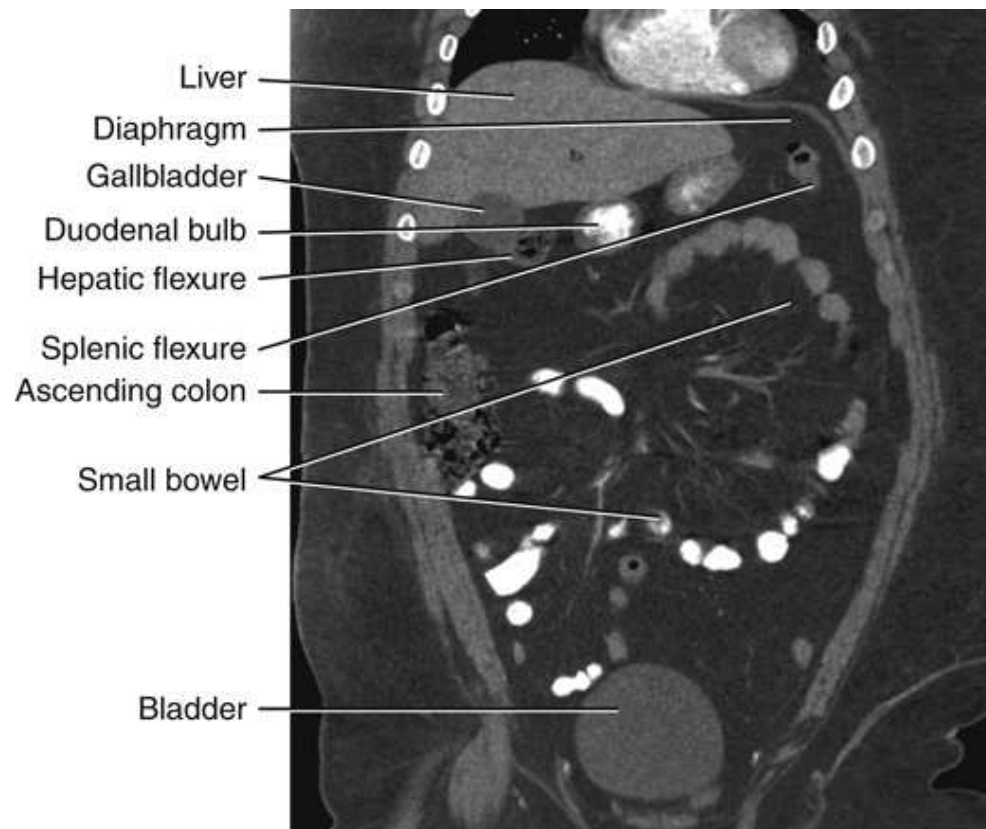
Coronal CT image through anterior abdomen.
